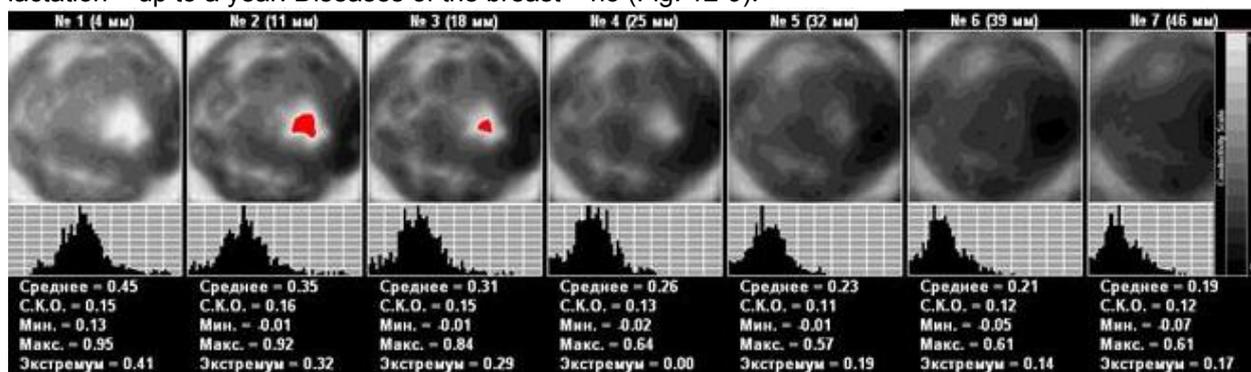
EIM. Outer segment. Fibrous type of mammary gland structure. In the outer segment of the right gland there is observed an an-impedance area, which is highlighted with red in two scan planes, 24x24 mm in size. ULTRASOUND: In the outer segment of the right gland there is an an-echoic lesion of irregular shape, 2.6x1.7 cm in size, with parietal inclusions. Axillary lymph nodes are not visualized.
